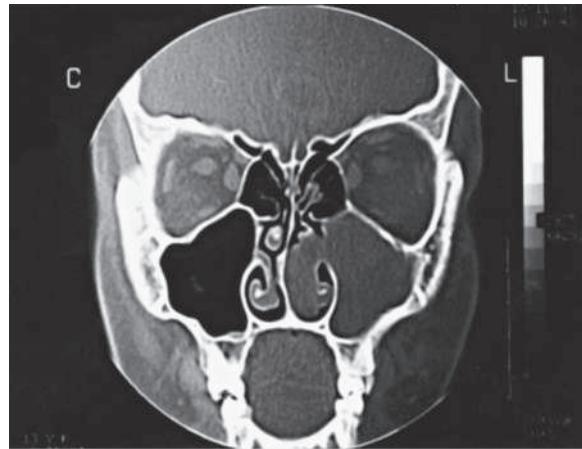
A typical CT image of an isolated antrochoanal polyp on the left side. (From Basak S, Karaman CZ, Akdilli A, et al. Surgical approaches to antrochoanal polyps in children. *Int J Pediatr Otorhinolaryngol*. 1998;46:197–205.)
